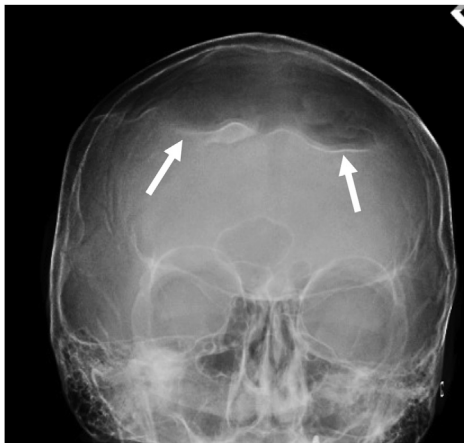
Frontal bone loss: skull radiograph revealing bilateral depression of the frontal bones and atrophy of the scalp soft tissue about the vertex of the frontal bone.
